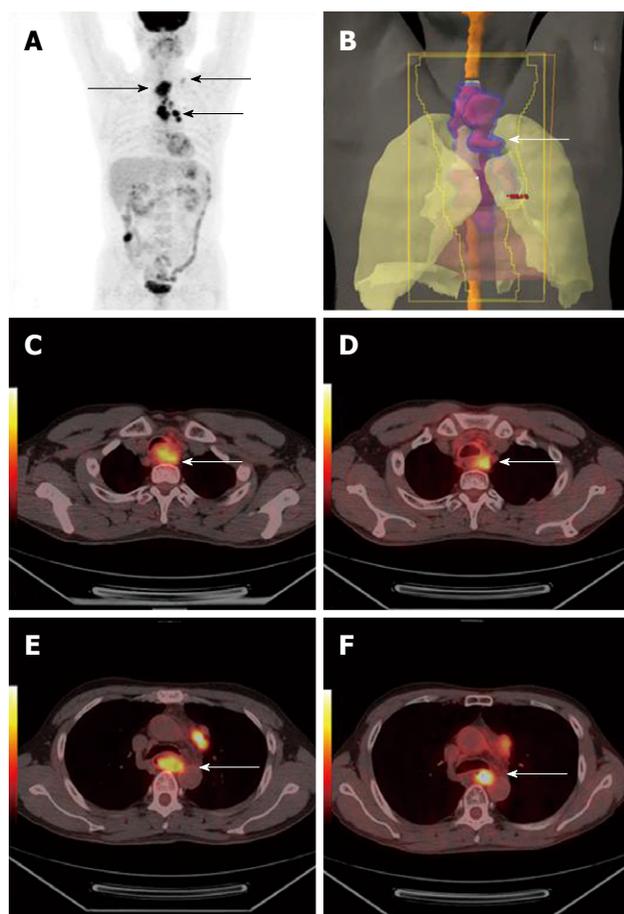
A 52-year-old man with synchronous multiple esophageal cancers. The first positron emission tomography/computed tomography (PET/CT) images revealed multiple hypermetabolic esophageal lesions and hypermetabolic supraclavicular, mediastinal lymph nodes (arrows in A, C, E). PET/CT imaging guided radiation plan (arrows in B). The second PET/CT images after 50Gy radiation treatment demonstrated shrinkage of lesions and decrease of fluorodeoxyglucose uptake (arrows D, F).
